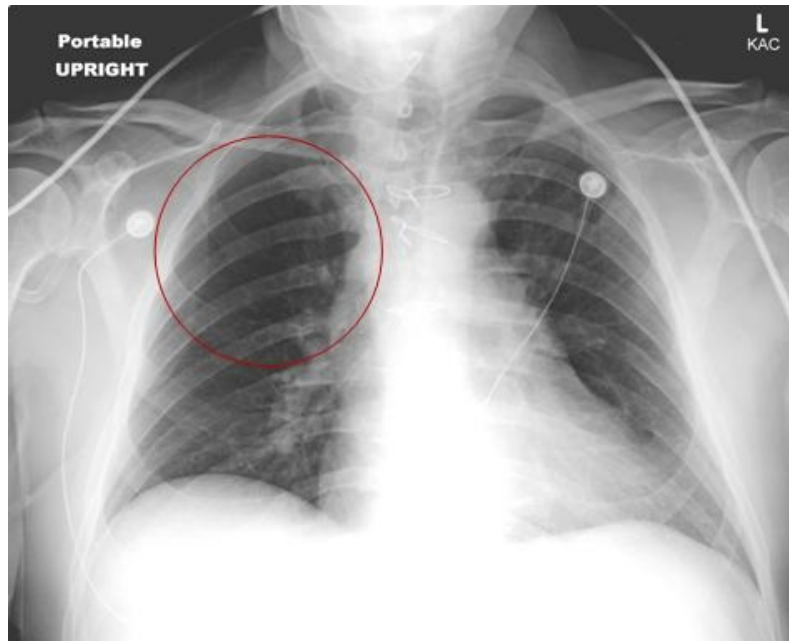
Chest x-ray showing decrease pulmonary vasculature on the right upper lobe (red circle, Westermark sign).
